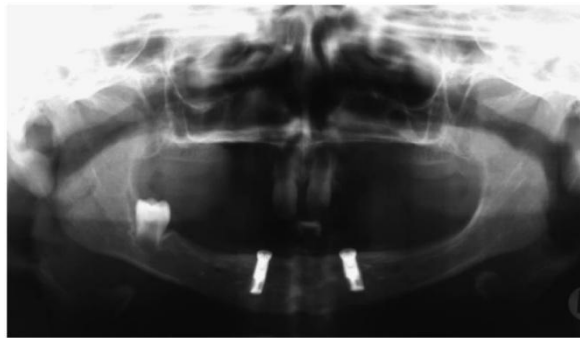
Panoramic control radiograph during the healing phase
